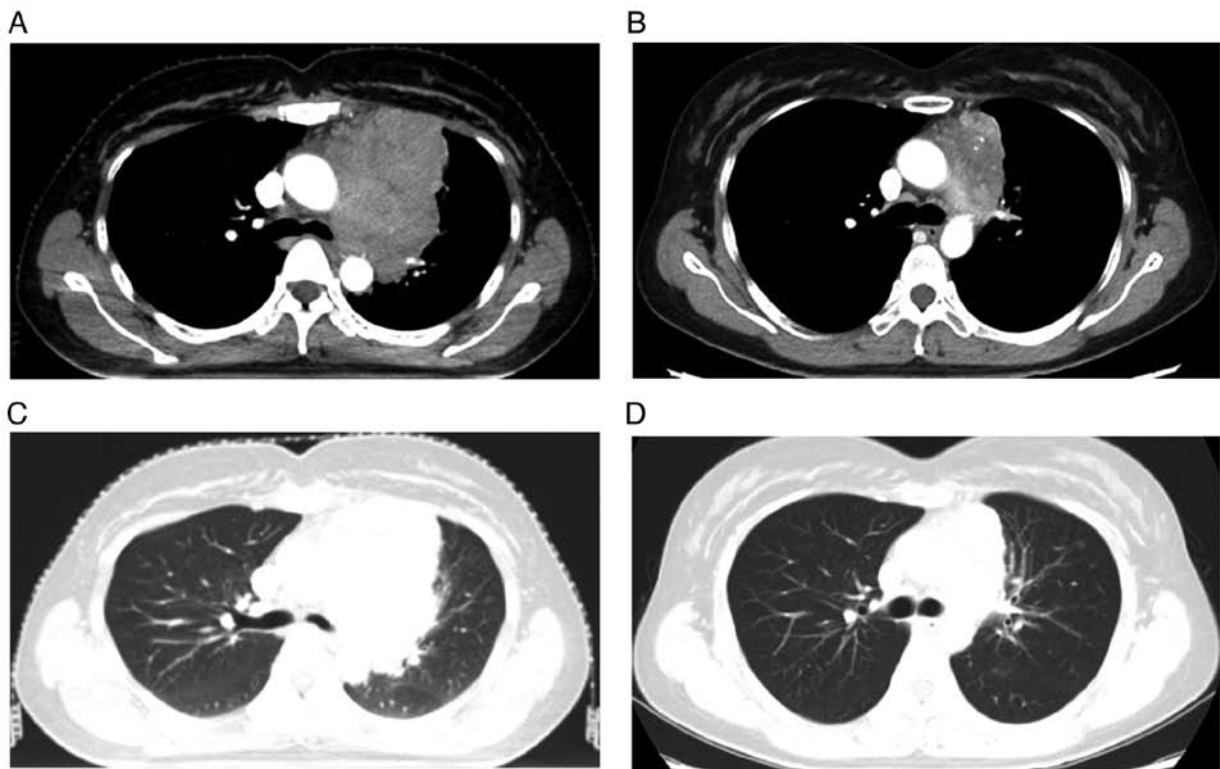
(A) Chest CT of the mediastinal window before radiotherapy. (B) Chest CT of the mediastinal window after radiotherapy. (C) Chest CT of the lung window before radiotherapy. (D) Chest CT of the lung window after radiotherapy.
